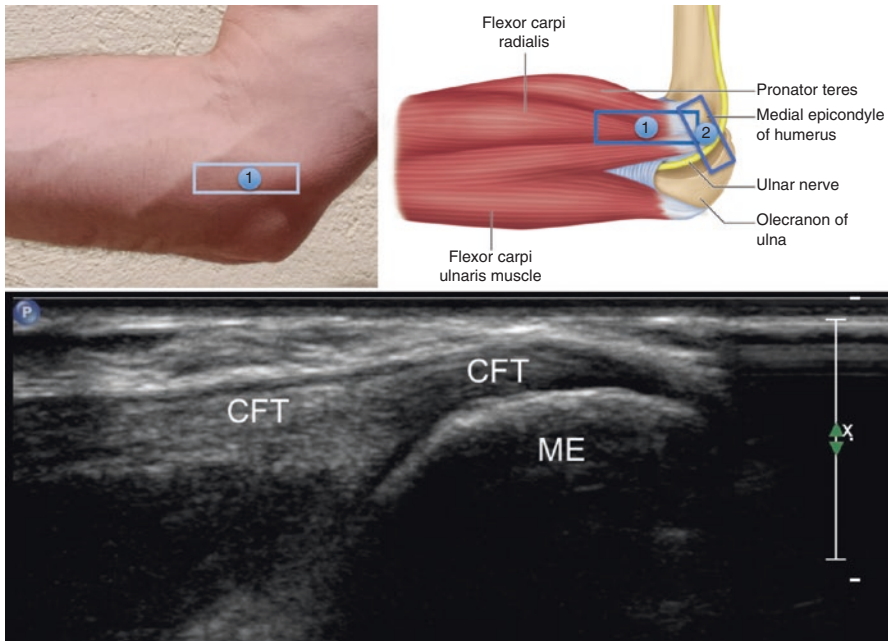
Sonoanatomy of medial elbow with the ultrasound probe in scan position 1
